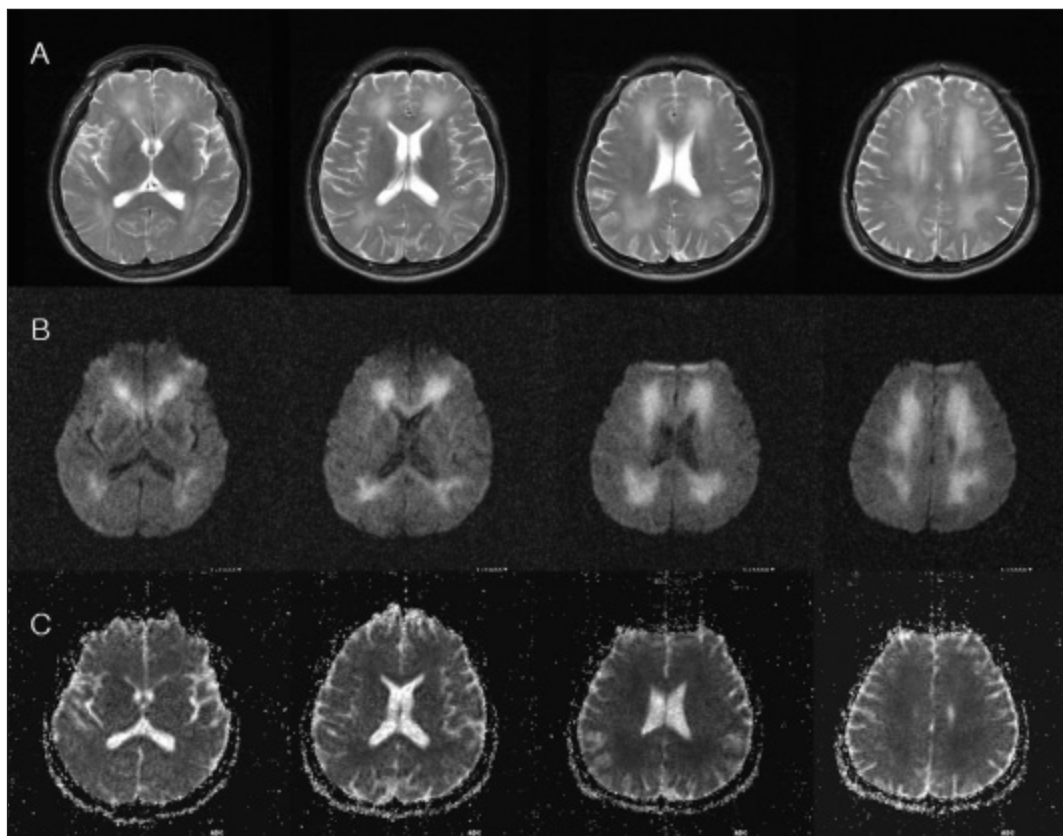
Brain magnetic resonance images demonstrate high signal intensities from bilateral periventricular white matter and deep white matter in T2-weighted (A) and diffusion-weighted images (B) and low signal intensities from comparable area in apparent diffusion coefficient maps (C).
